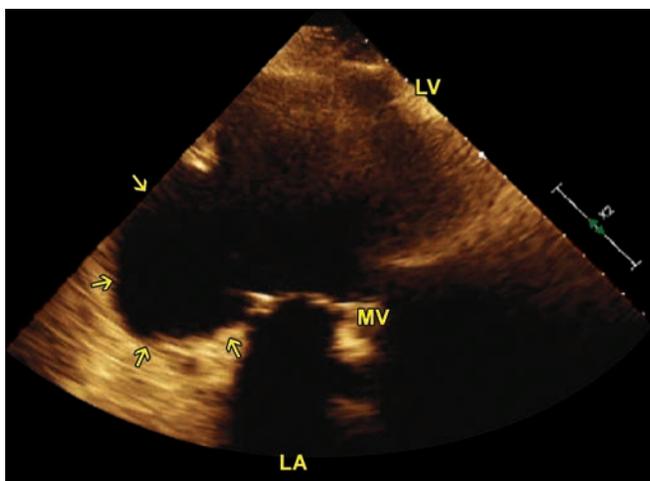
Transthoracic apical view showing a very large true LV aneurysm (arrows) with a wide opening.
